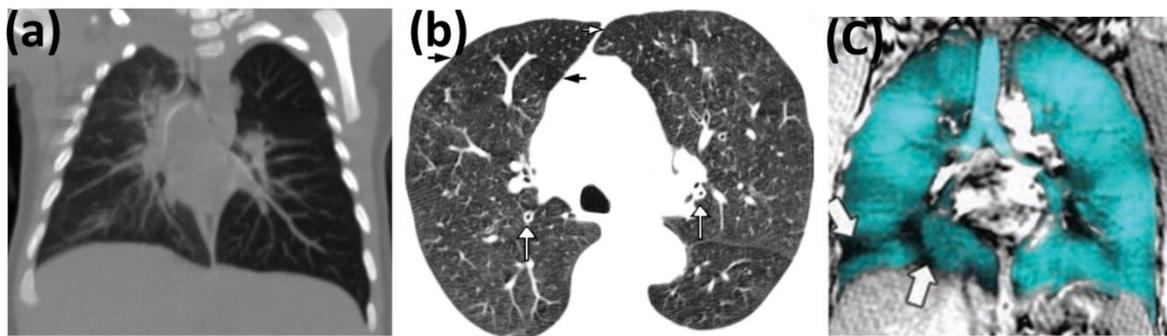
(a) Chest X-ray, (b) high-resolution CT scan, and (c) He MRI of different asthma subjects adopted with permission from [11, 13, and 14]
